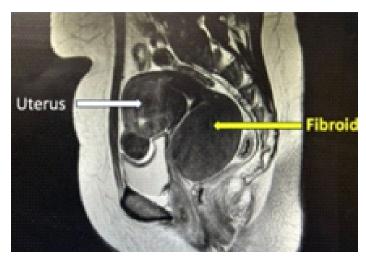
MRI showing a retroperitoneal fibroid.
